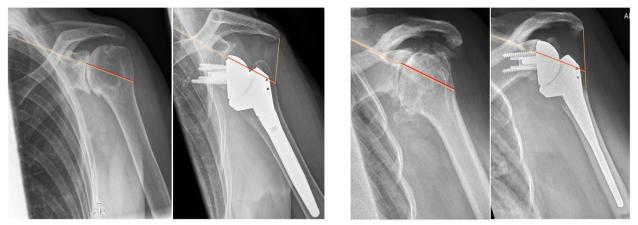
Glenoid-Greater-Tuberosity-Distance (GGTD) measurements performed at pre- and postoperative radiographs for two separate cases. On the left, the distance from the glenoid to the lateral point of greater tuberosity along the axis of the scapular spine is performed. In cases where the extension of the scapular spine (yellow line) does not cut the greater tuberosity, it was measured to its intersection with a line connecting the lateral greater tuberosity and the lateral acromion (as demonstrated on the postoperative radiograph on the right). The difference between those two measurements was defined as the net lateralization, which describes the net elongation of the remaining cuff after RSA implantation
